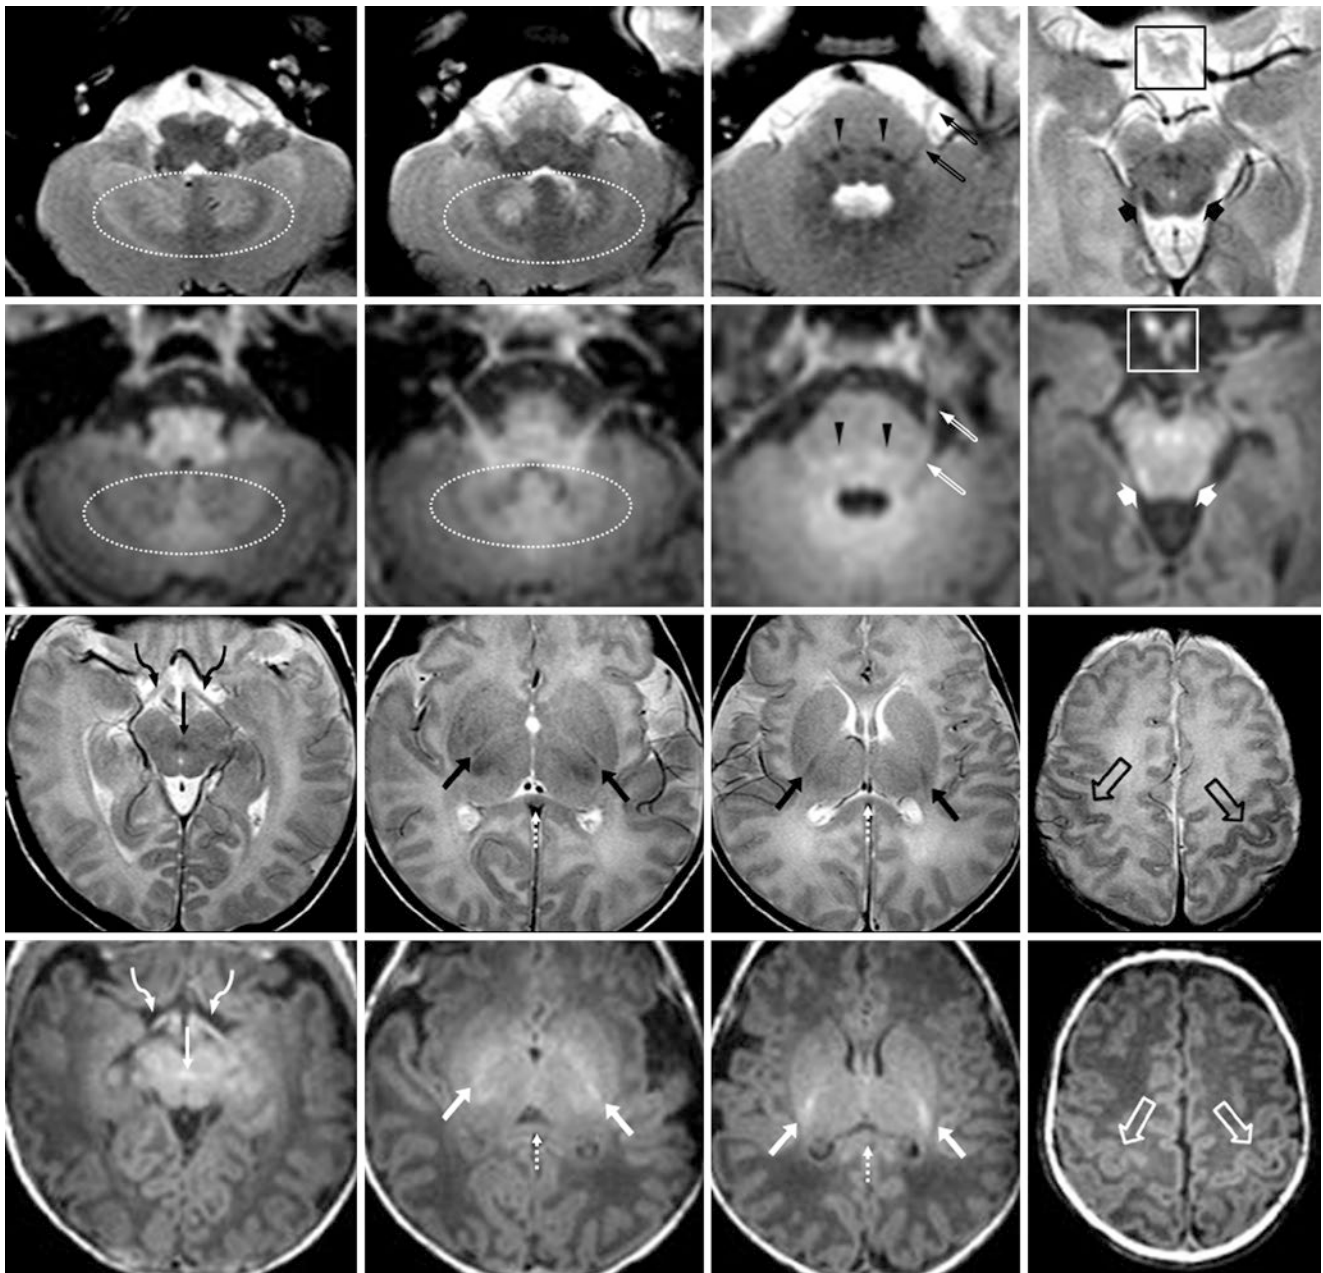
A 4-week-old with fevers but a negative 3T MRI. The patient was subsequently developmentally normal. *Top row:* SE T2WIs show darkening cerebellar white matter and nodule (*dotted ovals*), medial leminisci (*arrowheads*), left CNV (*beveled arrows*), and inferior colliculi (*wide arrows*). The ventral brainstem overall remains hyperintense. *Second row:* GE T1WIs do not depict the myelination of the cerebellar deep white matter and nodule as well, but the optic chiasm (OC) is better visualized as myelinated than on SE T2WI (*box*). The
